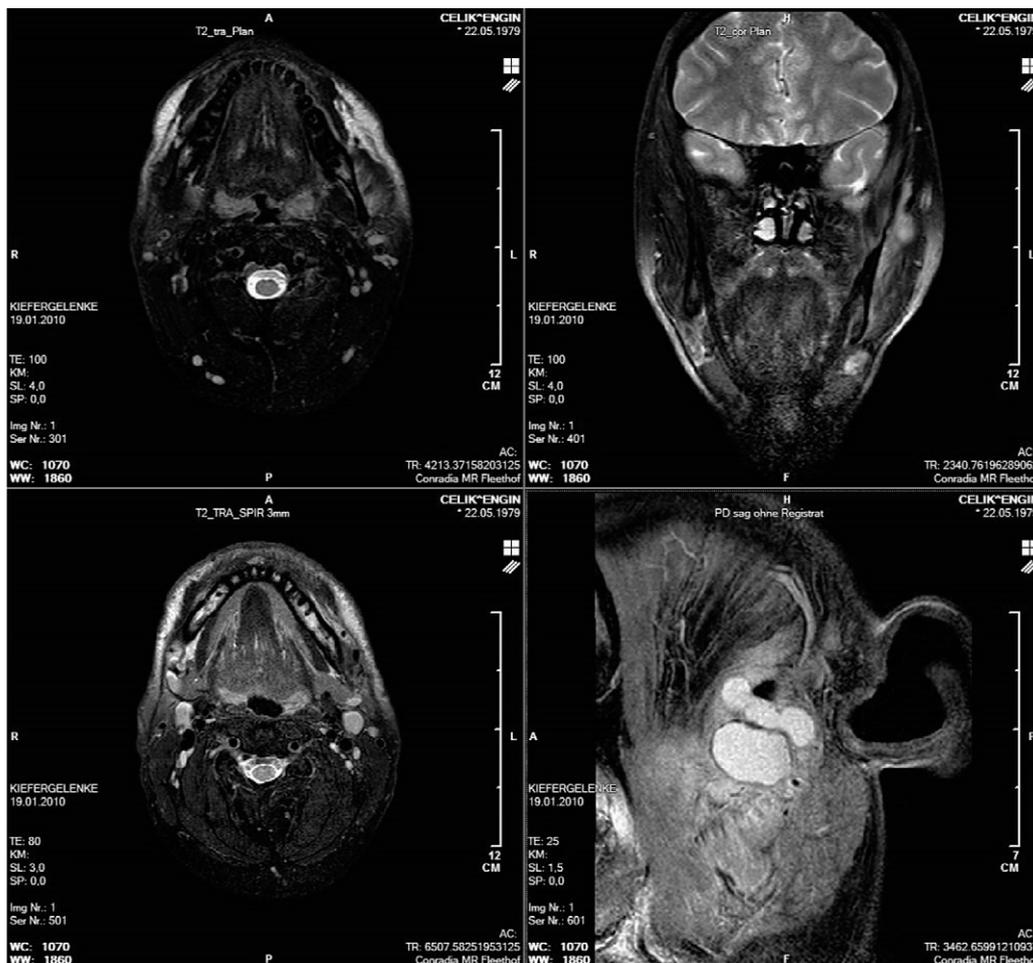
MRI reveals the lobular nature and extension of the lesion over the sigmoid notch.
